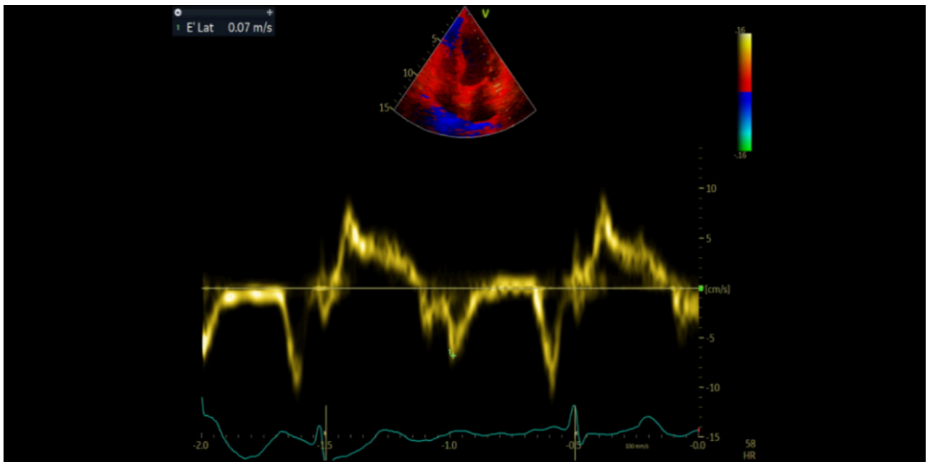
Tissue Doppler analysis of the lateral mitral annulus to calculate lateral e' in apical 4 chambers view
